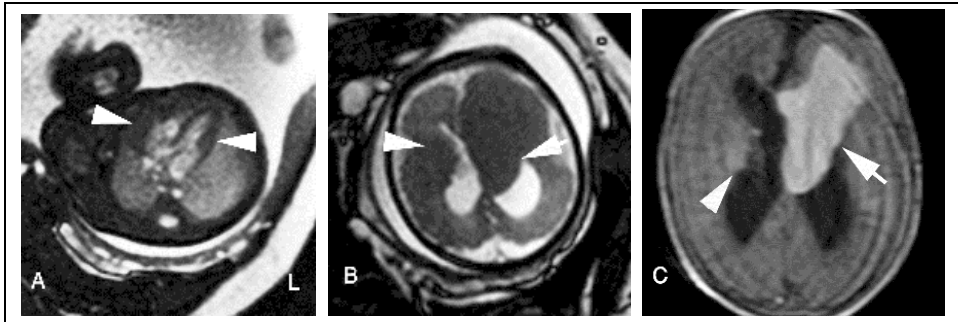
Subependymal lesions in association with cardiac masses suggest the prenatal diagnosis of tuberous sclerosis. In-utero MRI using T2-SSFP at 29 weeks' gestation, of the chest (A) revealed multiple cardiac rhabdomyomas (arrowheads) associated with multiple cerebral subependymal masses (B) along the right lateral ventricle (arrowhead) as well as a large giant-cell astrocytoma of the left foramen of Monro (arrow). Postnatal axial post-contrast MRI of the brain of the same case at the age of 7 days (C) documents enhancing congenital subependymal astrocytoma of foramen of Monro (arrow) as well as the non-enhancing subependymal tubers at the right lateral ventricle (arrowhead).
